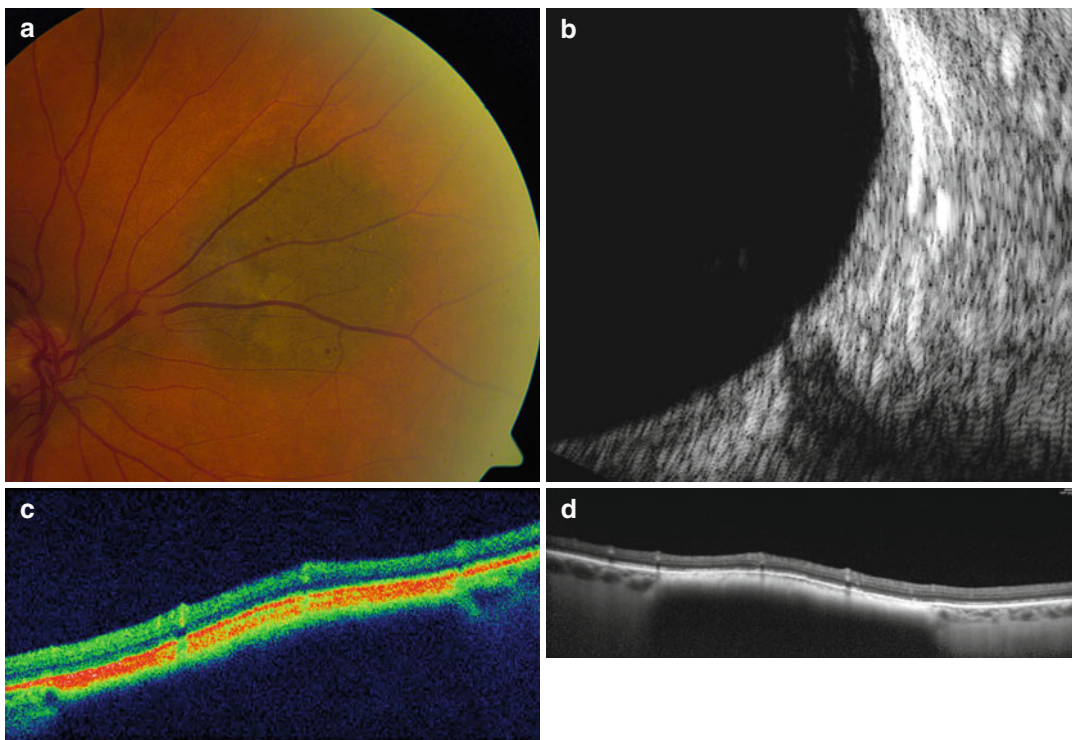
Choroidal melanocytic nevus. Fundus appearance (a). B-scan ultrasound is unable to detect the lesion (b). Spectral-domain OCT (Topcon-1000). The lesion appears as a sharply highly reflective band at the Bruch's/RPE/choriocapillaris layer (c). Spectral-domain OCT EDI
